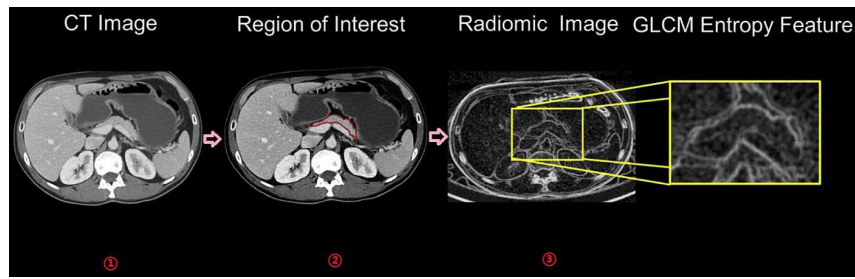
CT scan and radiographic feature image analysis (The steps of feature extraction from radiographic images include: ① acquisition of radiographic images; ② identification of regions of interest on the acquired images; ③ extraction of radiographic features from regions of interest.).
